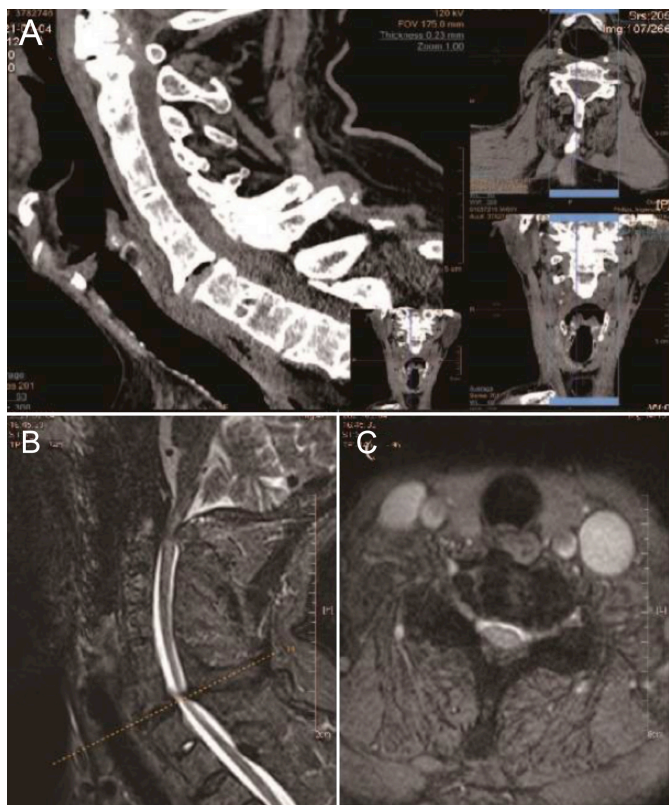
(A) Computed tomography of the cervical spine indicates anterior I° spondylolisthesis of the C6 vertebral body and C6/7 vertebral instability. (B, C) Magnetic resonance imaging of the cervical spine suggests small patchy T2WI hyperintensity in the spinal cord at the C1-2 level.
